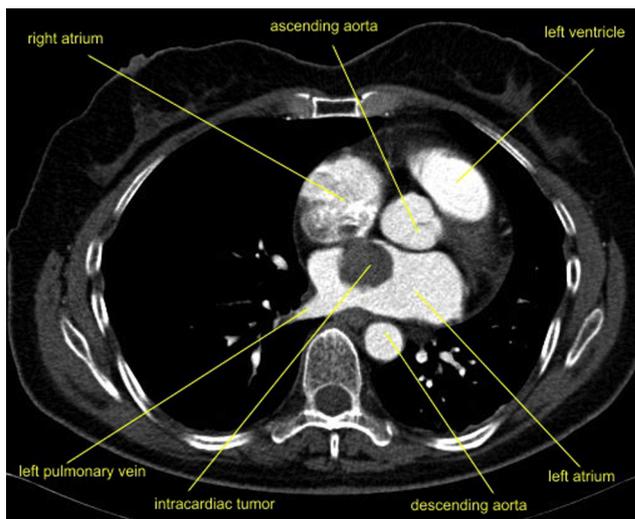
CT image after intravenous contrast administration, transverse plane, tumor mass in the left atrium.
